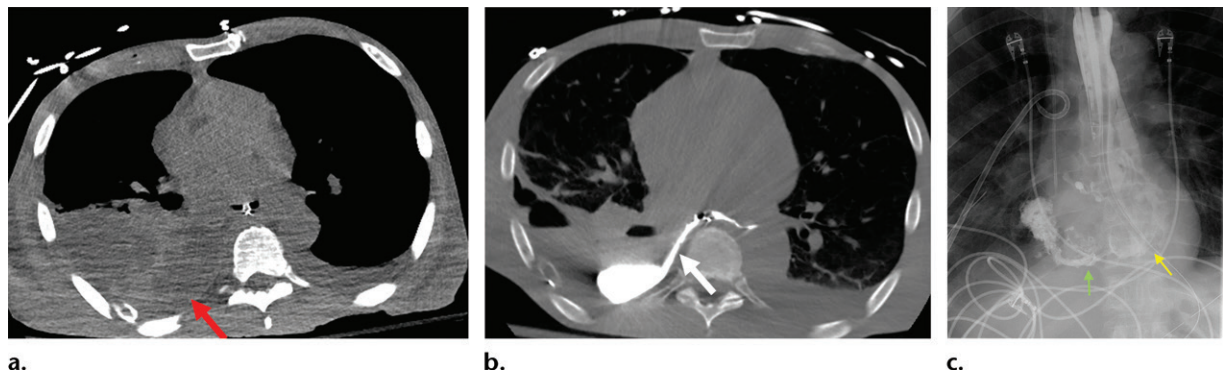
Esophageal leak in a patient who recently underwent esophagectomy and gastric pull-up. (a) Fluoroscopic esophagram shows leakage of contrast material from the esophagectomy site. The exact site of the leak was unable to be ascertained during fluoroscopic esophagography as the patient was critically ill and difficult to reposition. (b) Axial CT esophagram obtained without intravenous contrast agent clearly demonstrates the posterior defect in the esophagectomy site (arrow), allowing surgical planning.
